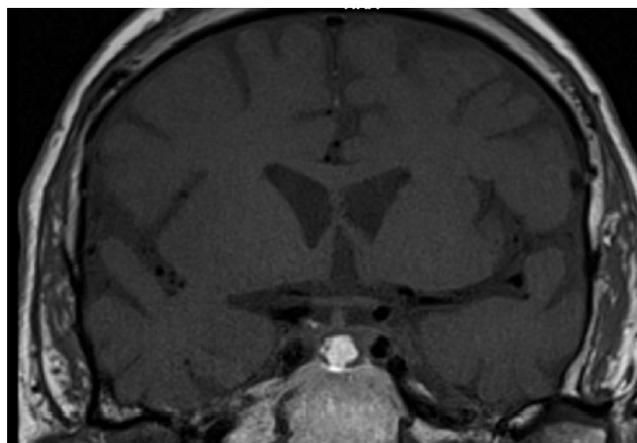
Head MRI – pituitary hemorrhage focus. Cavernous sinus invasion not present.
